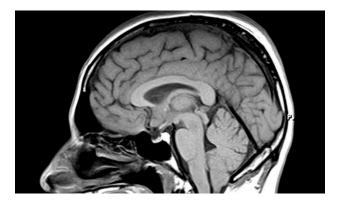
MRI of brain showing Arnold CM.
